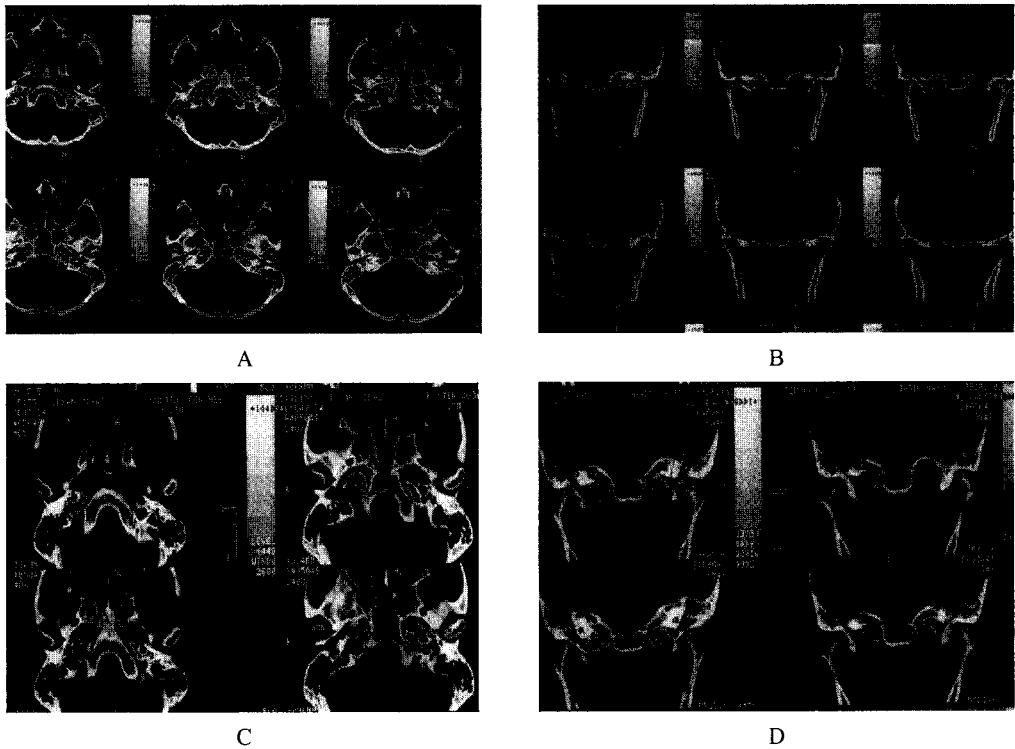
CT showed that the size of subcondylar cyst at left condyle was not increased.
